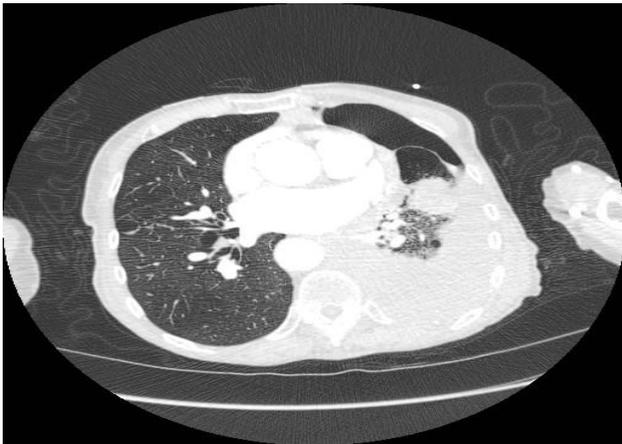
Axial view chest CT scan. Mass lesion in left lung lower lobe with left sided hydro-pneumothorax.
